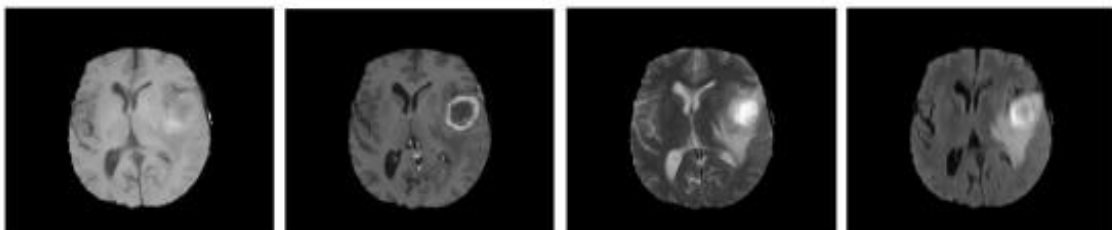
Standard MRI diseases
